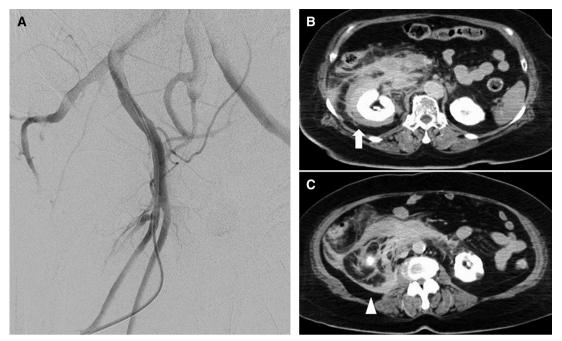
Right femoral angiography showed no evidence of extravasation (A). Abdominal computed tomography showing a perinephric (arrow) (B) and retroperitoneal (arrow head) hematoma (C).
